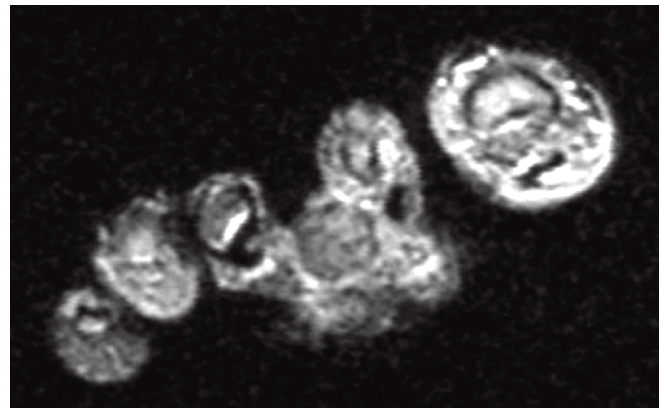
T2-weighted image of same lesion shown in Figure 15 demonstrating the hypointensity of the lesion.
